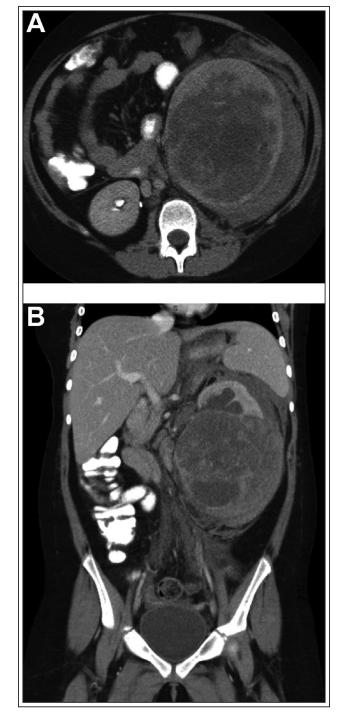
Axial (A) and sagittal (B) CT urogram showing a mixed solid and cystic left-sided renal mass.
